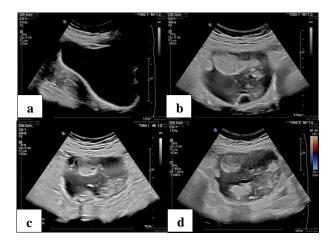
Transabdominal ultrasonography images of 30-year-old female with mature cystic teratoma shows (a) normal uterine cavity with no G-sac, (b) and (c) complex solid -cystic mass in right adnexa, the right ovary is not visualized separately, and (d) color doppler images shows no internal vascularity within the solid component.
